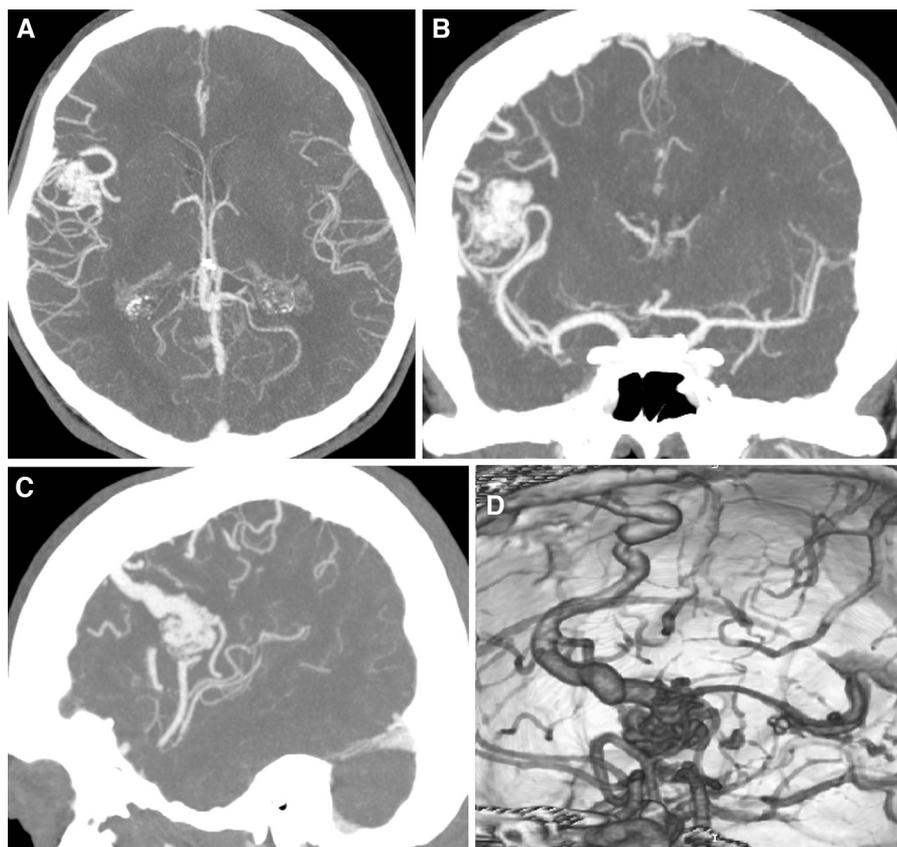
Preoperative images. Axial (A), coronal (B), and sagittal (C) CT angiograms showed a small (<3 cm) right perirolandic arteriovenous-malformation. On 3D volume-rendered CT reconstruction (D) one dilated vein draining into the superior sagittal sinus was presented (contralateral view).
